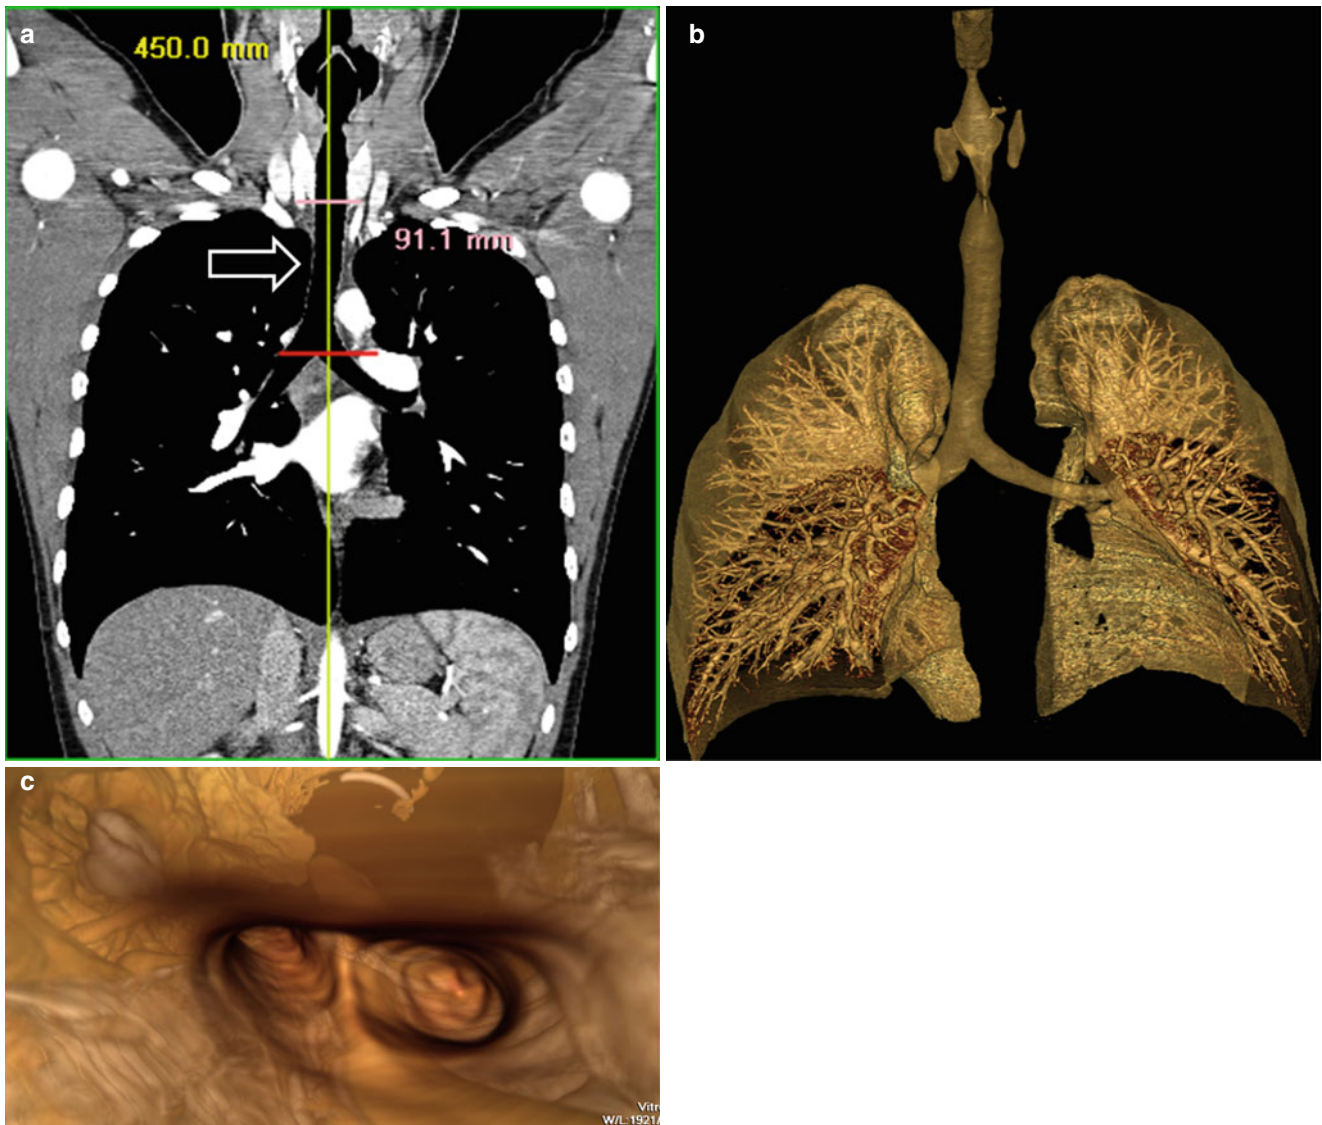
Normal large airways of a 5-year-old girl. (a) Curved coronal reformatted CT image demonstrates a straightened view of the entire trachea (*arrow*). (b) Three-dimensional volume-rendered image of the patent large airways and lungs. (c) Three-dimensional volume-rendered
